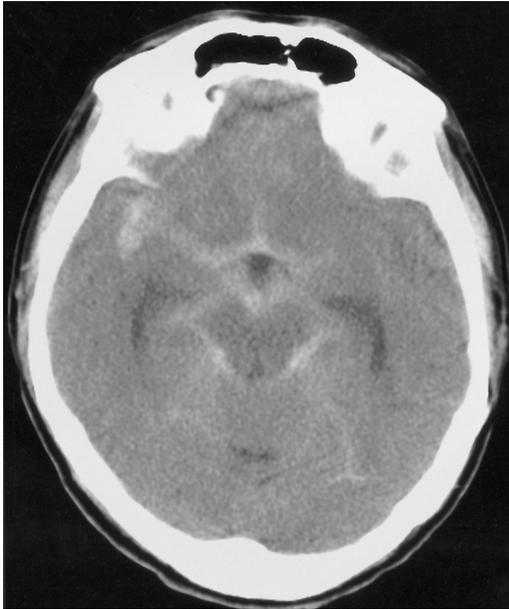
Brain CT shows high-attenuation along the right Sylvian fissure, interpeduncular cistern, suprasellar cistern, and ambient cistern, suggesting subarachnoid hemorrhage. The ventricular system is shown to be mildly dilated.
